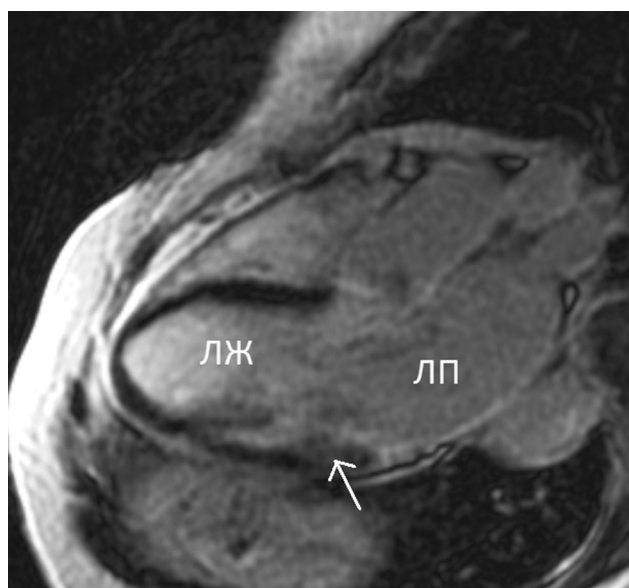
Cardiac MRI. Three-chamber view. Late gadolinium enhancement. The arrow indicates a low-intensity intramural zone of contrast accumulation at the level of 5th segment left ventricle. ЛЖ — left ventricle; ЛП — left atrium
